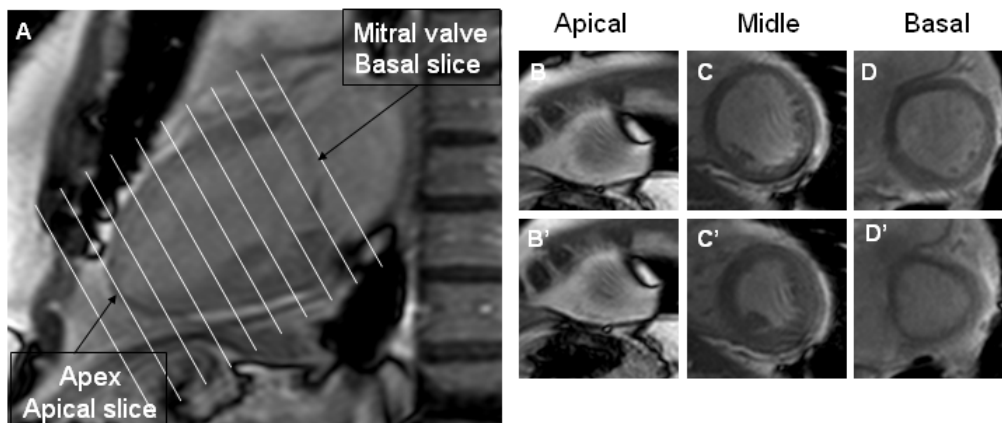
SA cine-MR images. (a) Long axis view and planing of the SA images (b) Apical slice (c) Middle slice (d) Basal slice. Top row is at ED phase and inferior row at ES phase.
